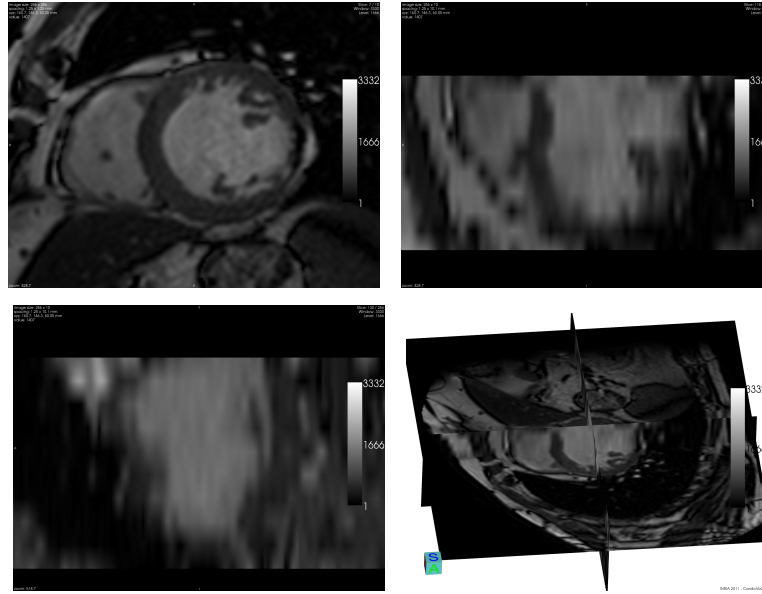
Example of cine SSFP MR images. Top Left: short axis view with resolution 1.25 mm x 1.25 mm; Top Right: Long axis view with resolution 1.25 mm x 10.1 mm; Bottom Left: Long axis (orthogonal) view with resolution 1.25 mm x 10.1 mm; Bottom right: 3D view.
